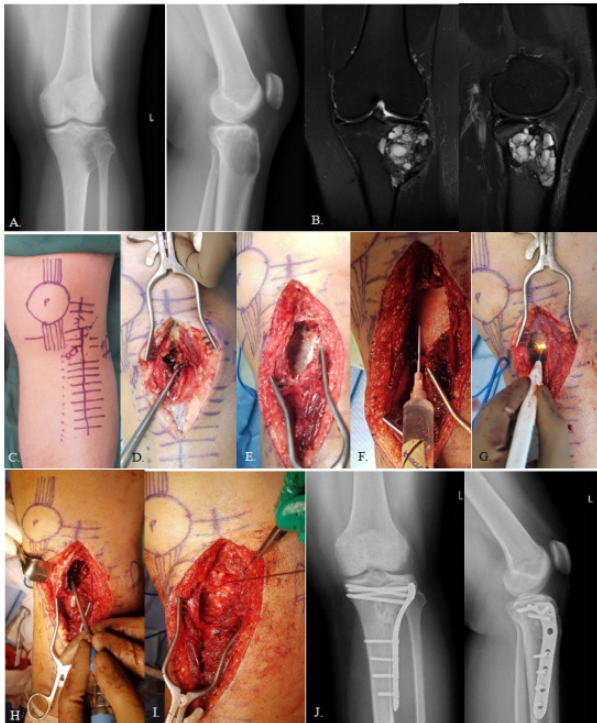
This demonstrates a case done under extended curettage. Preoperative radiographs (A) and MRI (B) reveal a Campanacci II GCTB of the proximal tibia and patient underwent surgery. Surgical markings (C) were done to map the landmarks, area of the lesion, and the planned incision. Curettage (D) was performed revealing grayish, friable tissue. Extended curettage followed using ethanol (E), hydrogen peroxide (F), electrocautery (G), and use of a highspeed burr (H). Bone grafting (I) was done using autologous iliac bone graft adjacent to the articular surface and morselized femoral head allograft to fill the rest of the defect. Postoperative radiographs (J) show placement of a 4-hole L-plate to the medial aspect of the proximal tibia, augmenting the construct.
